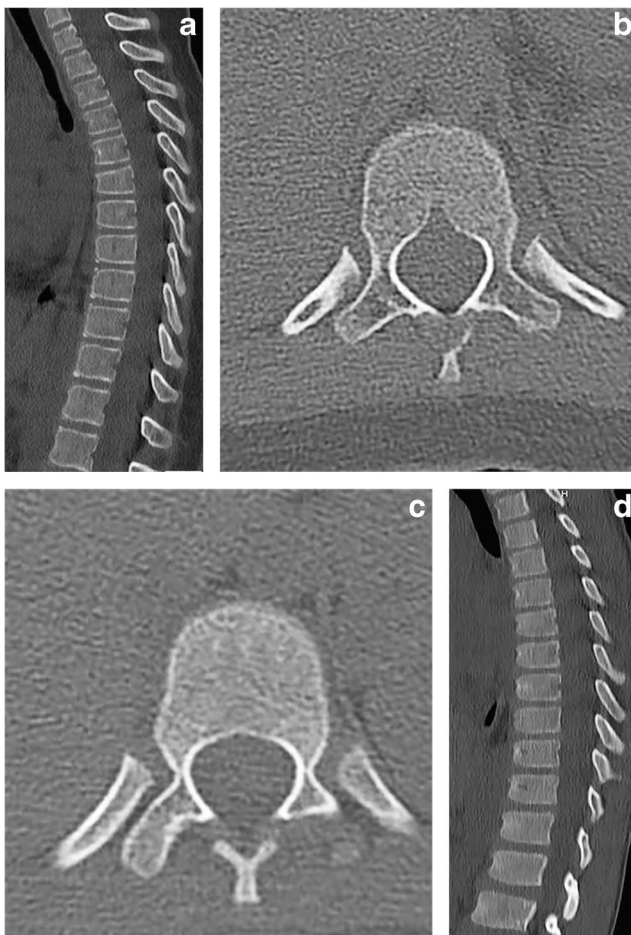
Image comparisons at different dose levels. a, b Thoracolumbar spine CT images reformatted in the sagittal plane (a) and axial plane (b) at the T11 level in a 9-year-old girl. Images were obtained with 110 kV, 85 mAs and collimated slice width value of 0.6 mm. The scan length was 58.4 cm and the dose-length product (DLP) was 397.0 mGy·cm. The girl's body mass index (BMI) was 20.8 kg/m². c, d Thoracolumbar spine CT images reformatted in the axial (c) and sagittal (d) planes at the level of the T11 vertebra in a 9-year-old boy. Images were obtained with 110 kV, 81 mAs and collimated slice width value of 1.2 mm. The scan length was 59.7 cm and the DLP was 187.4 mGy·cm. The boy's BMI was 21.3 kg/m². Note that both studies provide optimal contrast resolution for image interpretation
